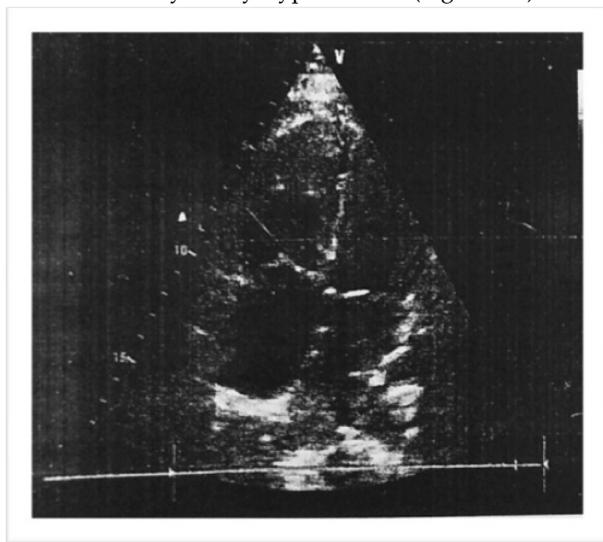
Echocardiography showing dilated right atrium and right ventricle.
